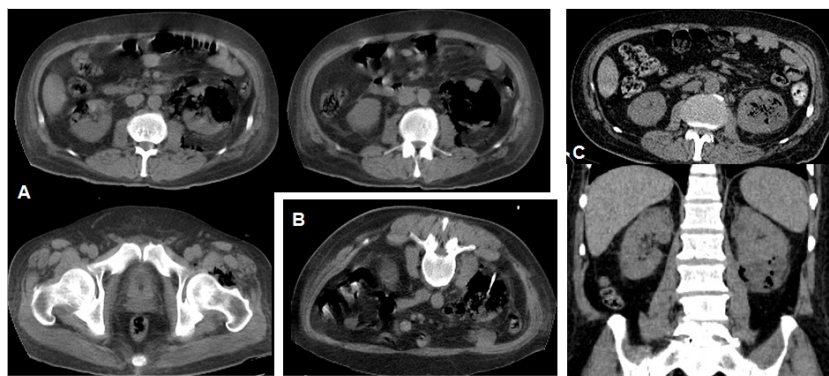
(A) CT scan of abdomen at admission revealing diffusely enlarged kidneys with perinephric edema, extensive gas bubbles in kidneys (most severe in left), and in left retroperitoneal, para psoas, deep gluteal and upper thigh soft tissues; (B) Percutaneous catheter drainage in left kidney on second day; (c) CT scan after 4 weeks revealing remarkable improvement of EPN.
